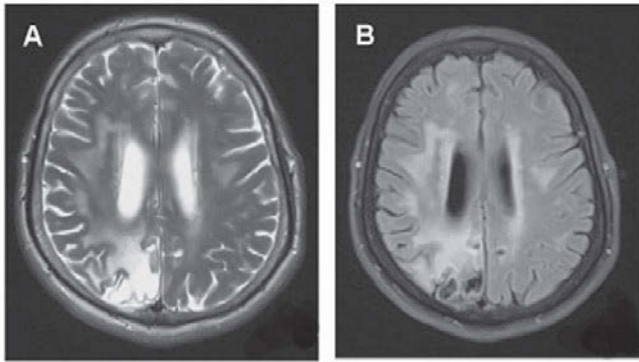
T2-weighted (A) and FLAIR (B) images performed after 8 months shows residual changes of brain tissue as cavitation and gliosis of the right occipital lobe.
